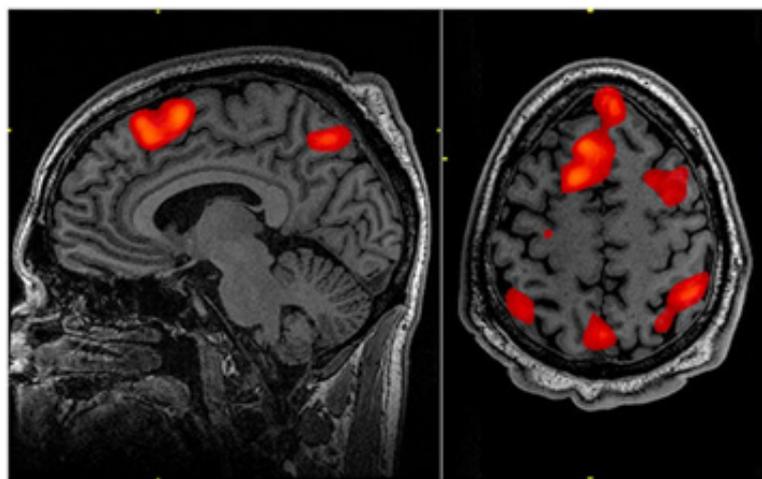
An MRI scan with the default mode network highlighted in red. On the sagittal scan (left), the anterior red region is the medial prefrontal cortex, and the posterior red region is the precuneus. On the axial scan (right), the lateral posterior regions in red are the left and right angular gyri [2].
